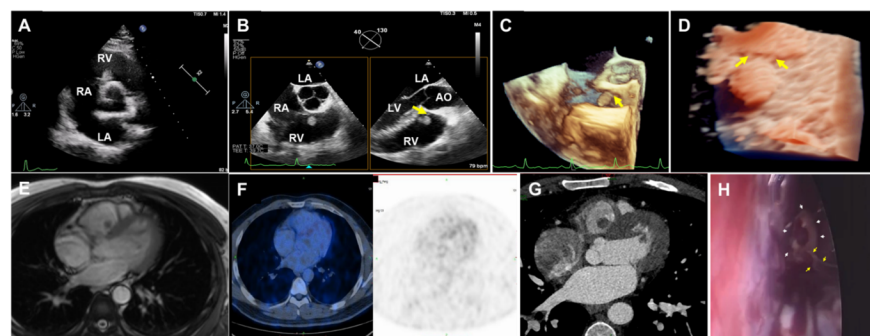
(A) Transthoracic echocardiogram showed a RV mass at the basal level of the interventricular septum; (B~D) Transesophageal echocardiography showed the attachment closely connected with the tricuspid tendinous cord (yellow arrows) and adjacent to the aortic root; (E) Cardiac magnetic resonance imaging showed a soft tissue signal nodule; (F) PET showed no obvious abnormal increase of metabolism in the right ventricle; (G) CTA showed a RV filling defect; (H) Thoracoscopy revealed the mass (the white arrows indicated its outline) and its attachment adhered to tendinous cord (little yellow arrows) of tricuspid septal valve.
